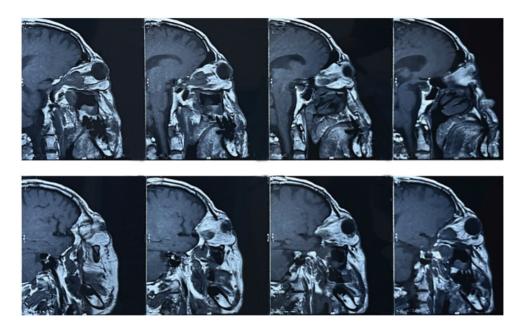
Orbital magnetic resonance imaging-2.
